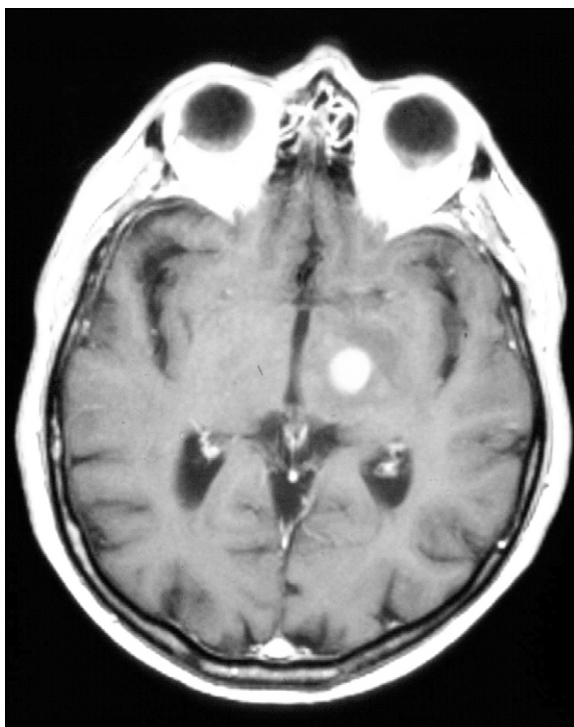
MRI showing primary CNS lymphoma involving the basal ganglia. This patient initially presented with contralateral hemichorea.
